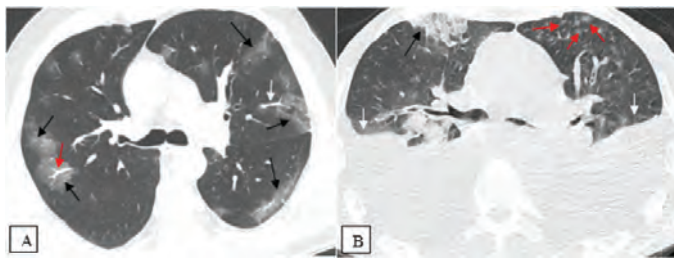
Axial CT images showing. A) Multifocal/multilobar GGOs with predominantly peripheral in distribution (A, black arrows) in a 61-year-old immunocompetent male patient presenting with cough, myalgia, and dyspnea, who had no comorbidities and who was discharged from the hospital 19 days later. Note also the perilesional (A, white arrow) and intralesional (A, red arrow) microvascular proliferation and B) A patchy peripheral GGO with superimposed areas of consolidations in the right middle lobe (B, black arrow) in a 69-year-old immunocompromised male patient presenting with cough, fatigue, and fever, who had a history of gastric cancer and died 24 days after being hospitalized for COVID-19 pneumonia. Note the presence of obvious bilateral pleural effusion (B, white arrows) in this immunocompromised patient in addition to multiple small centrilobular nodules with tree-in-bud appearances (B, red arrow) in the left lung, which was probably associated with bacterial superinfection
